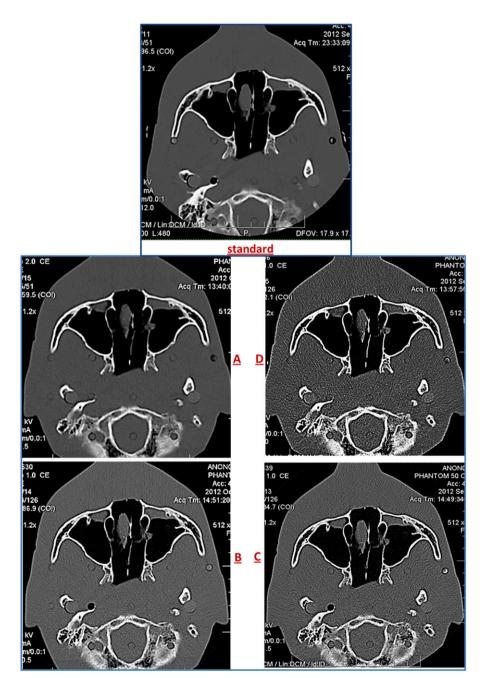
Axial sections of bone window (window level and width are 700 HU and 3000 HU, respectively) scanned at levels of maxillary sinus revealed the variations in image quality (image noise) of different multidetector CT (MDCT) protocols: (Standard) standard MDCT protocol (Standard), (A) Protocol VII, (B) Protocol VII, (C) Protocol IX and (D) Protocol X.
